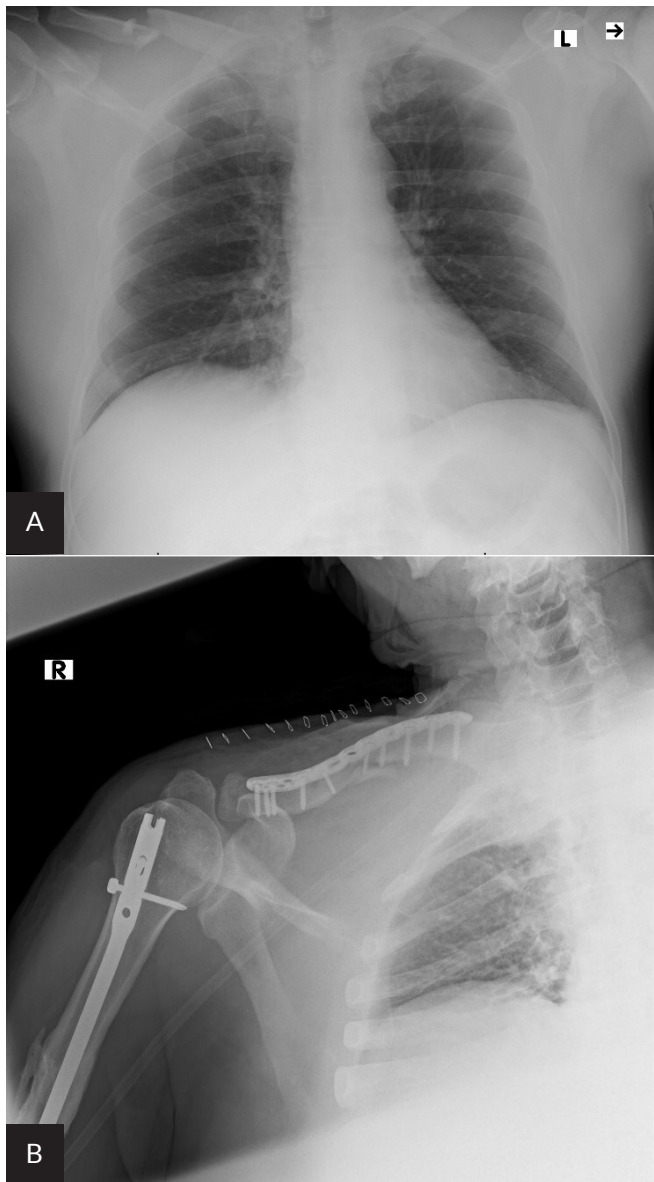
Case 7. X-ray. A. After conservative treatment. B. After surgery
